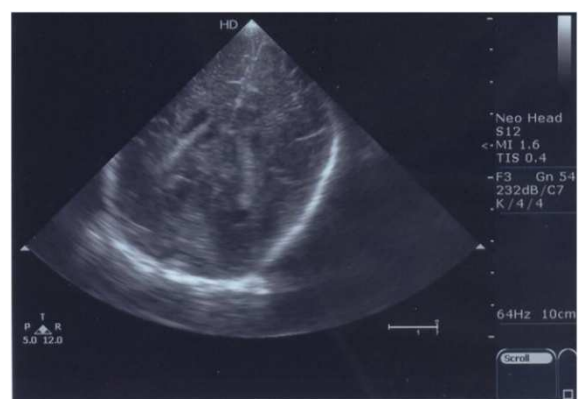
Cranial ultrasound coronal scan shows periventricular and cortical diffuse hypoechogenicity and abnormal echogenicity with loss of definition of the cerebellum suggestive of haemorrhage
